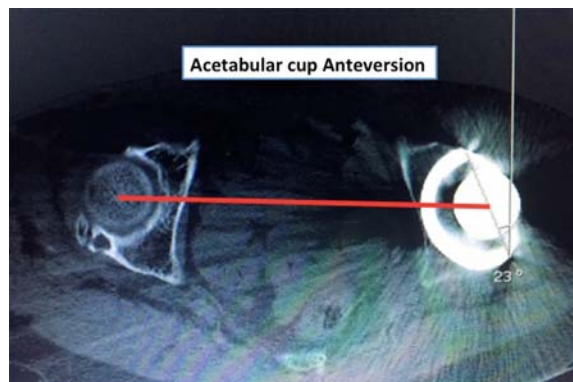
Measurement of the acetabular cup anteversion from CT scans of both hips converted to radiographic anteversion by the Murray equation for applying to the Lewinnek safe zone.
